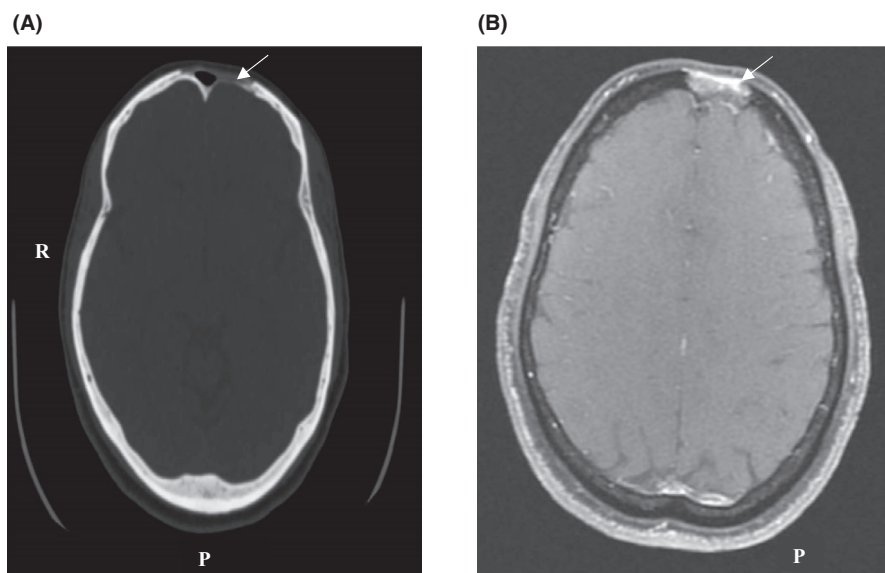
The lytic bone lesion on computed tomography scan (CT) and magnetic resonance imaging (MRI). A, CT scan showing a rounded lytic lesion of the frontal bone, left-sided, involving the walls of the frontal sinus, measuring 35 × 42 mm in diameter. B, Magnetic resonance imaging showing the frontal bone lesion, lateralized to the left, with hyposignal in T1-weighted sequences, enhanced after injection with gadolinium
